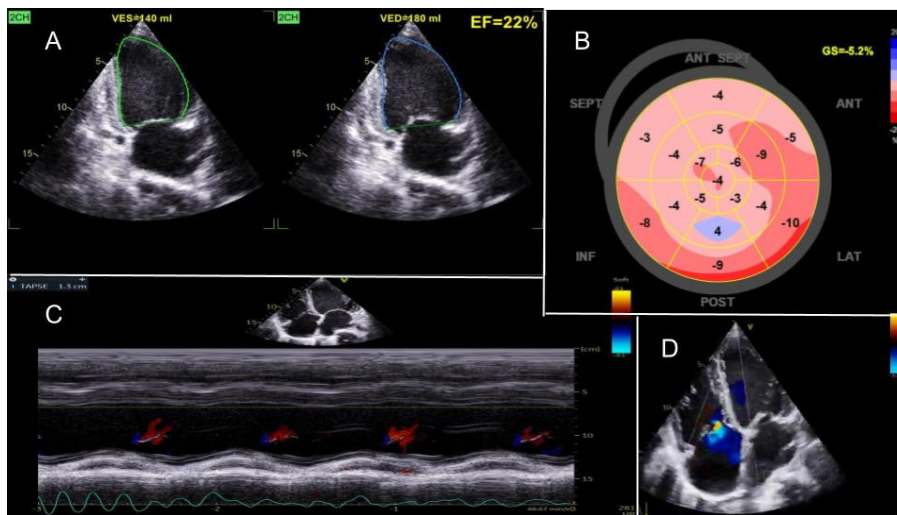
Baseline transthoracic echocardiography revealed: (A) Reduced LV ejection fraction (LVEF) of 23%; (B) Reduced LV GLS value of [-5.2%]; (C) Reduced RV systolic function (TAPSE 13 mm); (D) severe functional TR. LV: left ventricular; LVEF: left ventricular ejection fraction; GLS: global longitudinal strain; RV: right ventricular; TAPSE: tricuspid annular plane systolic excursion; TR: tricuspid regurgitation.
